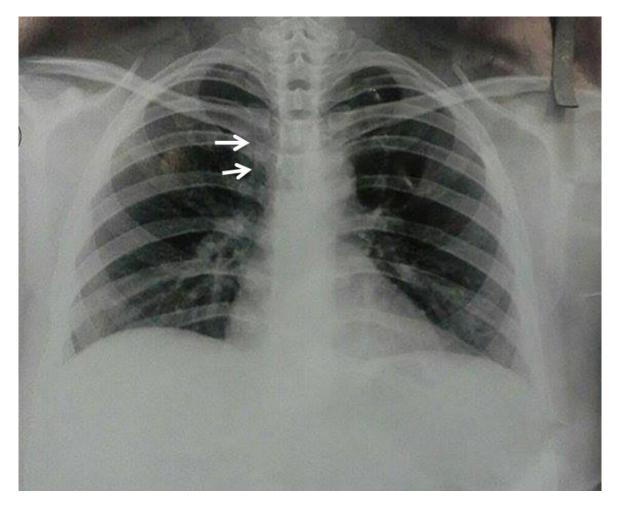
Chest x-ray PA view: showing small line in right upper lobe (white arrows)
